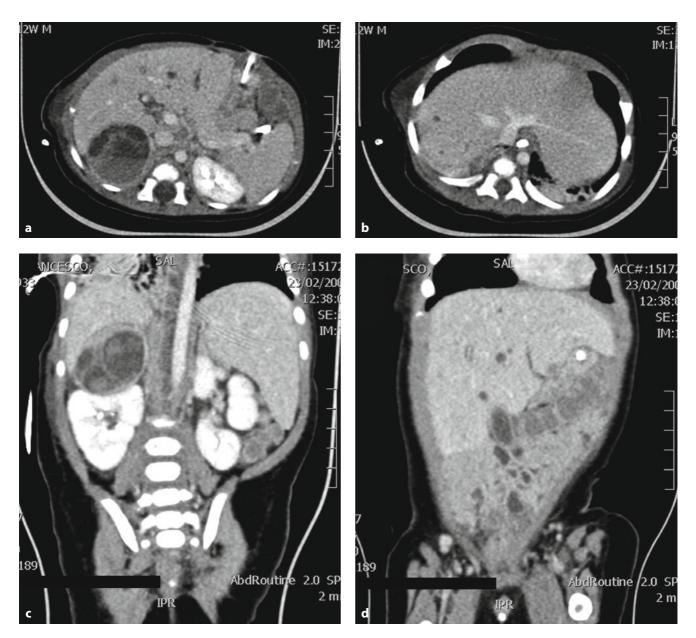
Neuroblastoma 4S CT imaging. Right adrenal lesion, mostly cystic necrotic (a–c) with hematic level. Multiple metastatic little epatic lesions are present (b–d). (Courtesy Dr. Marcello Napolitano)
